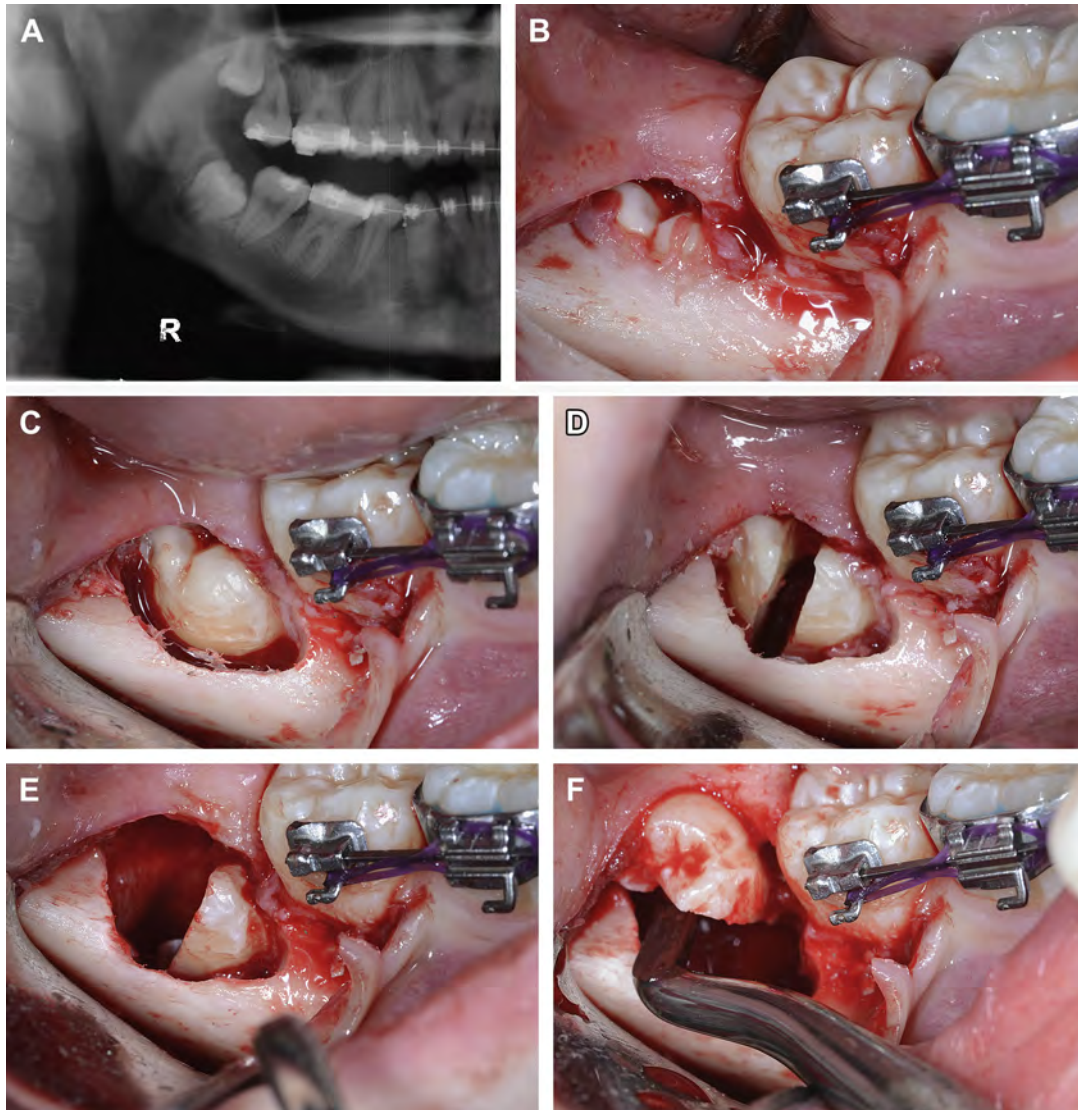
(A) Radiograph of mesioangular impacted mandibular third molar. (B) Reflection of soft tissue flap. (C) Buccodistal bone removed to expose crown. (D) Mesioangular third molar sectioned in half vertically. (E) Distal half of crown removed. (F) Mesial half of crown removed with elevator.
